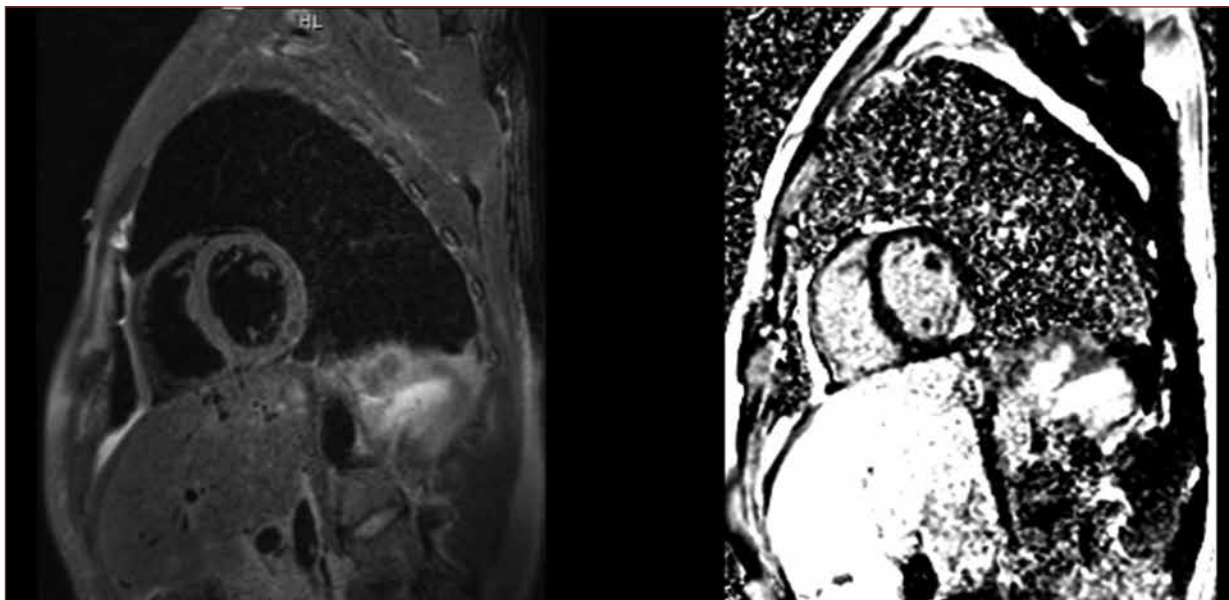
4 – Cardiac MRI (Mid segment) - Mild focal thickening of the inferolateral segment of mid left ventricle with heterogeneous mid myocardial to subepicardial late gadolinium enhancement in the post contrast image.
